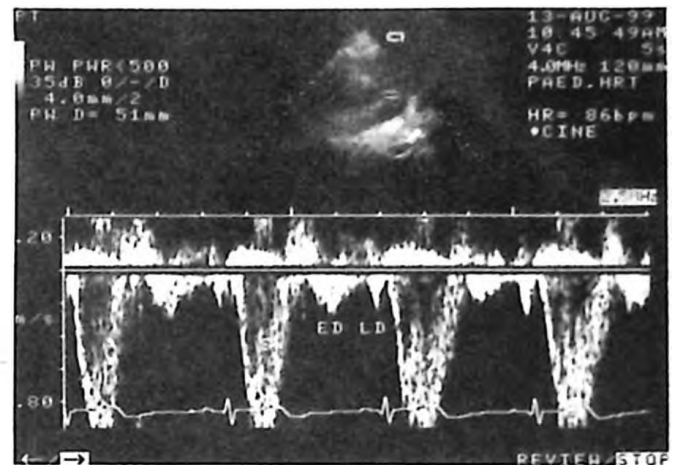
Pulsed-Doppler recording from the pulmonary artery of a normal child. S = systolic flow; ED: early diastolic flow; LD = late diastolic flow.
